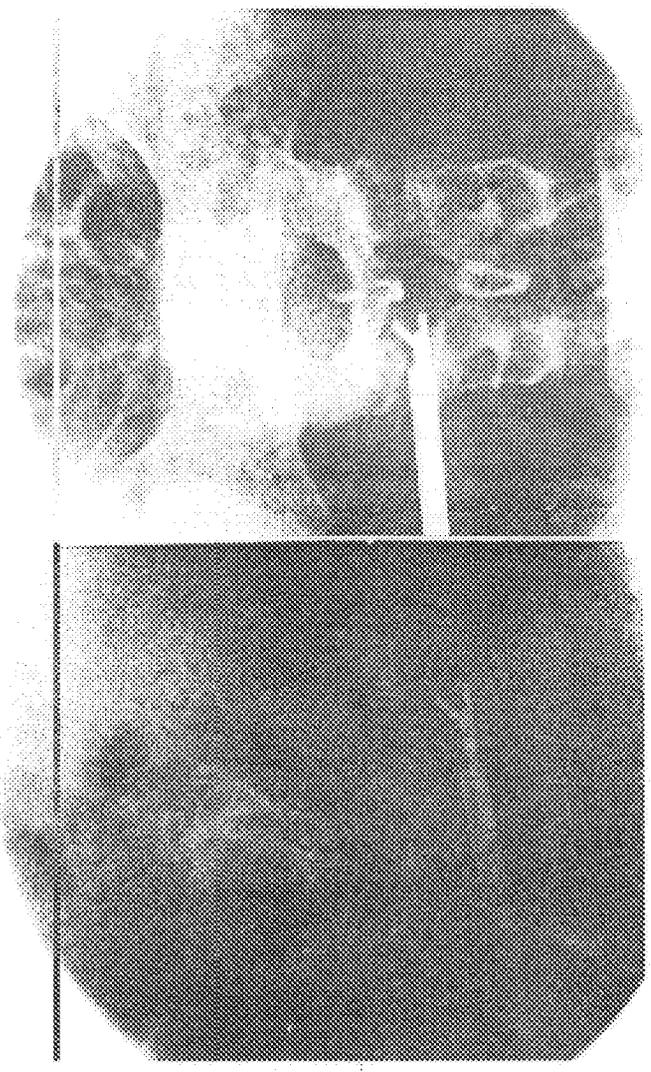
Roentgenographic documentation of position of the forceps.
